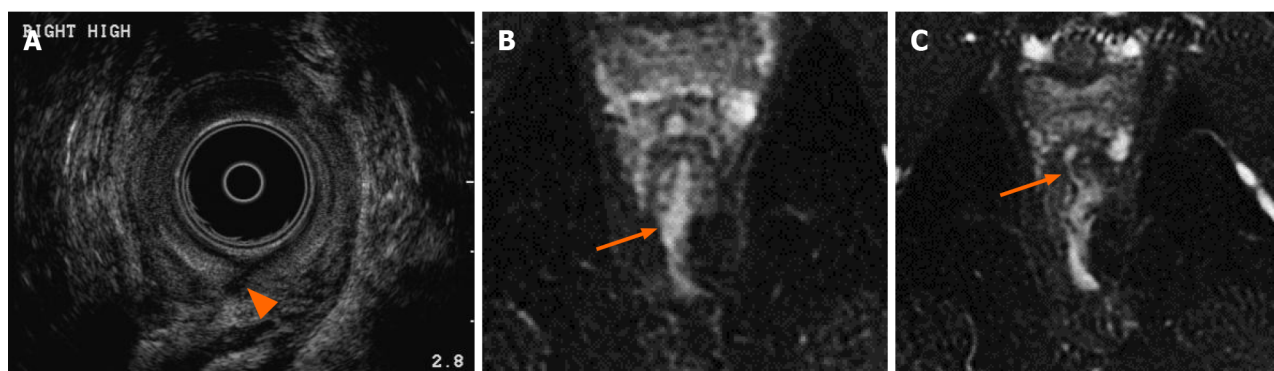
A 37-year-old-man with history of Crohn's disease. A: Transrectal ultrasound identifies a defect in the internal anal sphincter posteriorly (arrowhead); B: Axial T2 weighted, fat saturated image of the anal canal obtained 6 d later more clearly show a transsphincteric perianal fistula arising at 6 o'clock with a fluid filled sinus tract extending posteriorly to exit at the skin surface; C: Magnetic resonance imaging (MRI) image also demonstrates an additional transsphincteric fistula which arises at the 1 o'clock position extending anteriorly and communicating with a complex branching tract which also exited to the skin surface (not shown). MRI provides comprehensive multiplanar imaging of fistulizing disease, allowing visualization of the full extent of disease including supralelevator disease and more complete classification of branching or complex fistulas. Additionally, post contrast sequences allow differentiation between fluid containing tracts from granulation tissue seen following healing.
